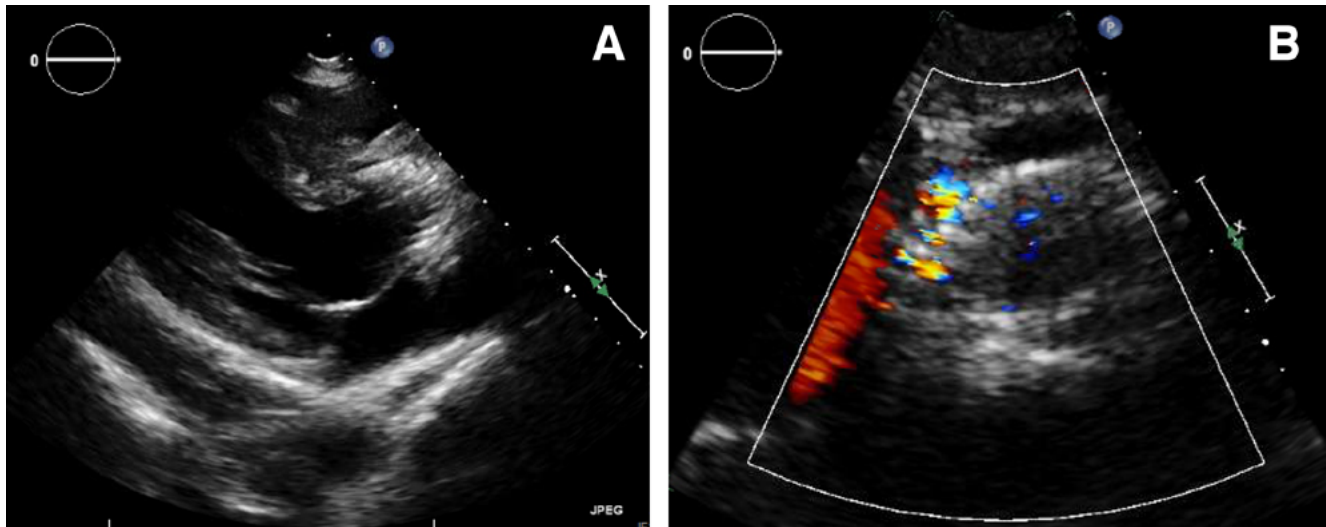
Panel A. Six-month follow-up transesophageal echocardiogram shows adequate positioning of the CoreValve in a parasternal long axis view. Panel B. Transesophageal echocardiogram short axis view of aortic valve showing turbulent flow suggestive of perivalvular leak.
